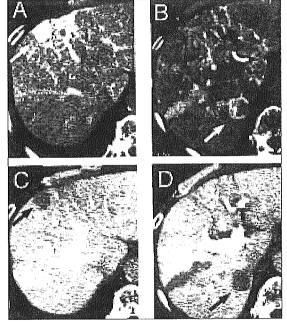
Computed tomography during hepatic arteriography (CTHA) (A and B) demonstrating a well-enhanced mass in segment 8 and ring-like enhancement mass in segment 7 (arrow). Computed tomography during arterial portography (CTAP) (C and D) demonstrating well-detected mass in seaments 7 and 8 (arrow).
